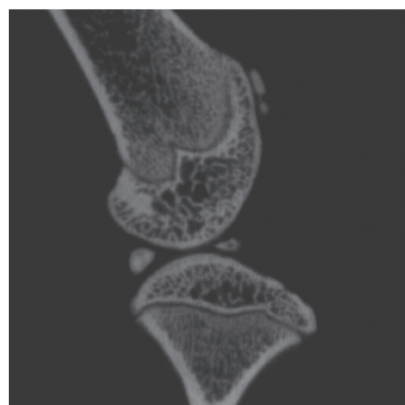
Extended TAA release in OA joints lead to large amount of dystrophic calcification. (a) 3D reconstruction of μ CT scans. MS-TAA 0.7 mg is employed as a typical example of all three loading doses. (b) Quantification of dystrophic calcification in experimental joint (L), corrected for the contralateral joint (R). Individual data shown for control (OA) $n = 6$, TAA bolus $n = 6$, MS-TAA 0.7 mg $n = 6$, MS-TAA 1.0 mg $n = 5$, MS-TAA 1.6 mg $n = 5$, healthy joints MS-TAA 0.7 mg $n = 6$, as well as mean \pm SD. MS, microspheres; * $P < .05$, significantly different as indicated
